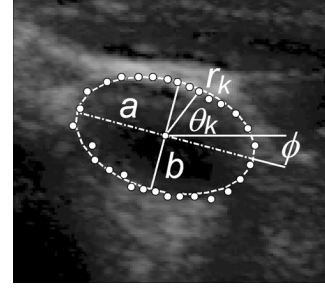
Ellipse model for transverse vessel area. A vessel contour in an ultrasound image can be approximated by using an elliptical model with parameters a , b , and ϕ . Each contour point can be described in polar coordinates by $r_k = f(a, b, \phi, \theta_k)$.
